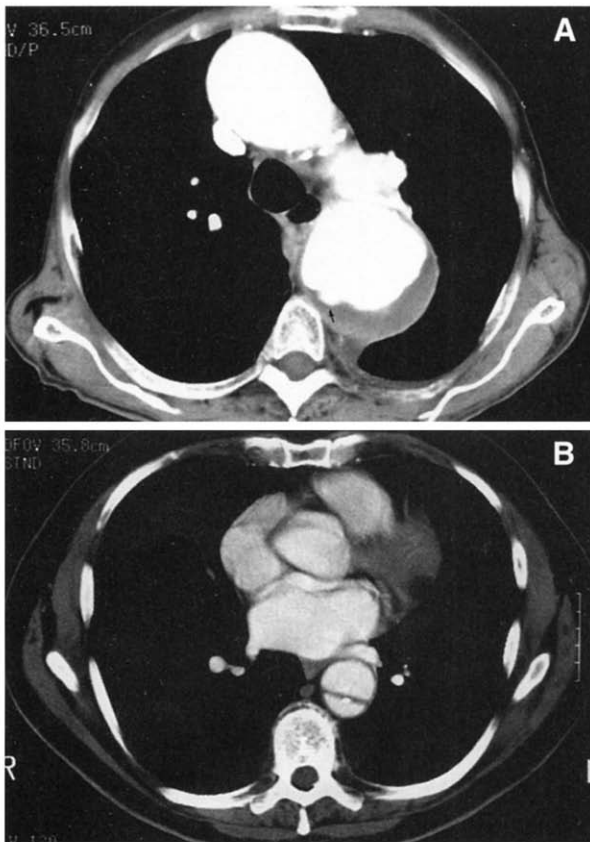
A, Computed tomographic scan of patient 3 (Table II) at middle level of the descending thoracic aorta. Clearly demonstrated is a contrast medium–filled penetrating ulcer. No intimal flap is seen. B, Computed tomographic scan shows classic type B aortic dissection for comparison. Intimal flap and both true and false lumens are present.
